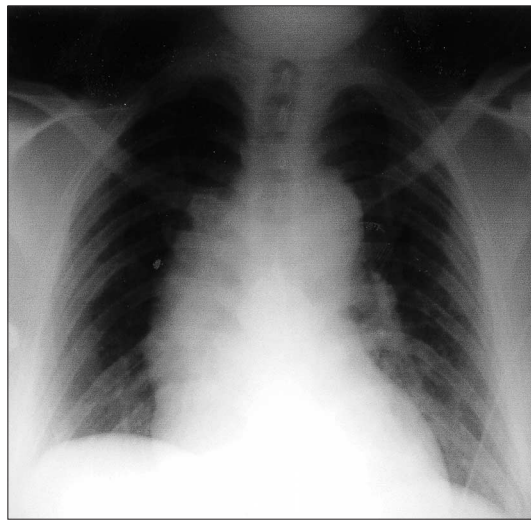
Chest X-ray showing widened mediastinum in patient with type A dissection.
